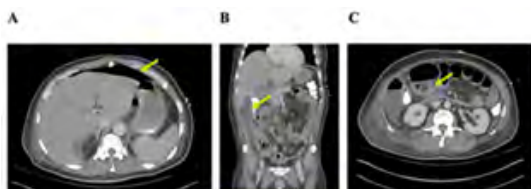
On hospital day 2, a repeat abdominal CT scan revealed large volume pneumoperitoneum (a), as well as a right pericolic abscess (b), and small bowel dilatation associated with the patient's prior small bowel anastomosis (c).
